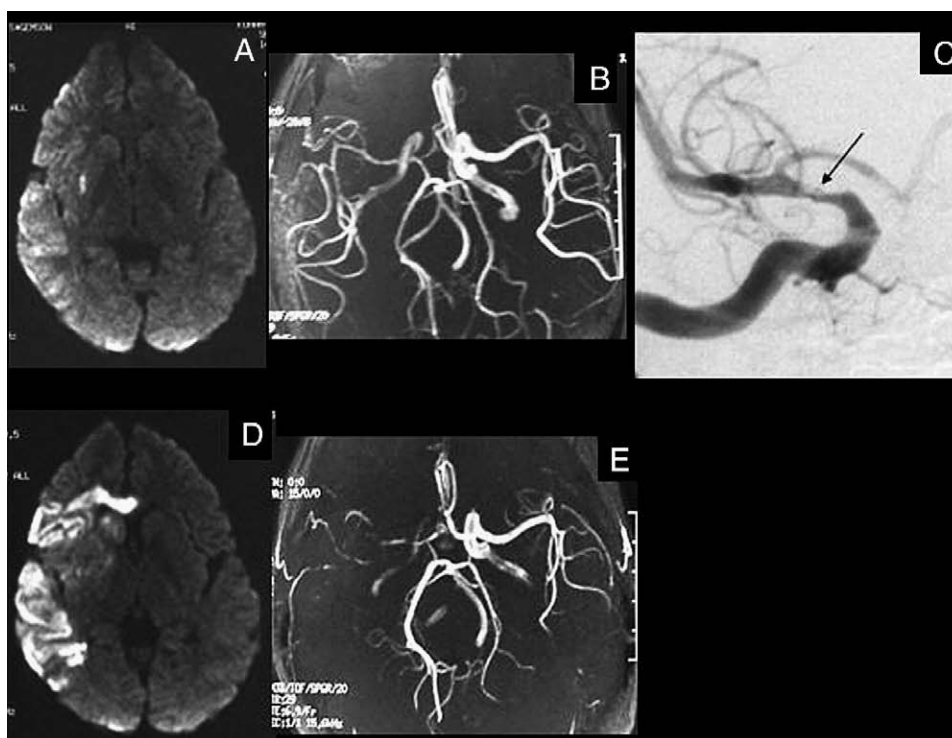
Images from case 43. Diffusion-weighted MR image (A) and MR angiogram (B), both obtained 2 hours after onset. Multiple infarctions are seen in the right MCA territory (A). Stenosis is present in the right ICA filled through the MCA (B). C: Conventional right carotid angiogram obtained just after the MR study showing stenosis with “double lumen” sign (arrow) at the supraclinoid portion of the right ICA and mild stenosis in the M1 segment of the right MCA. Diffusion-weighted MR image (D) and MR angiogram (E), both obtained on the 10th day after the onset. Right ICA and MCA are severely stenotic but patent.
